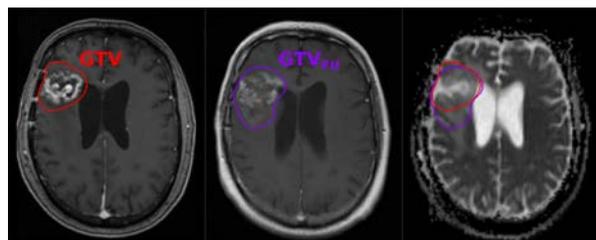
Exemplary images of a patient with recurrent glioblastoma. The T₁ CE MRI at treatment planning (left) and follow-up (middle) were used to delineate the analysis contours GTV and GTV_{FU}. These contours were mapped onto the DWI ADC map for analysis (right).
